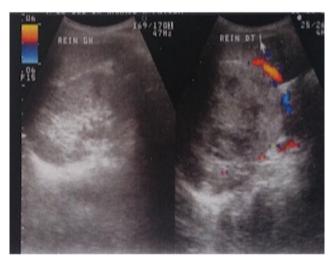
Subtype 2 of a papillary carcinoma in 68 years old woman. US shows a 10 centimeters hypoechoic and heterogeneous mass. In doppler, the tumor appears to be hypo-vascularized. The contours are focally irregular.
